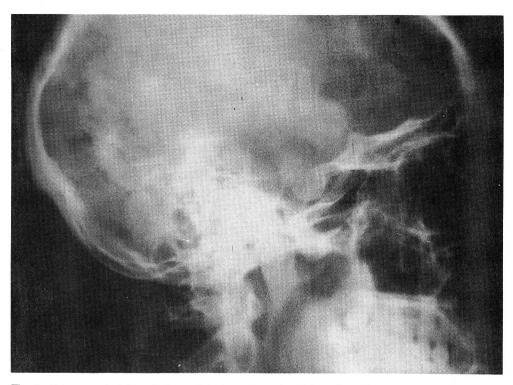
Plain x-ray skull (lateral) shows widening and erosion of the sella turcica.
